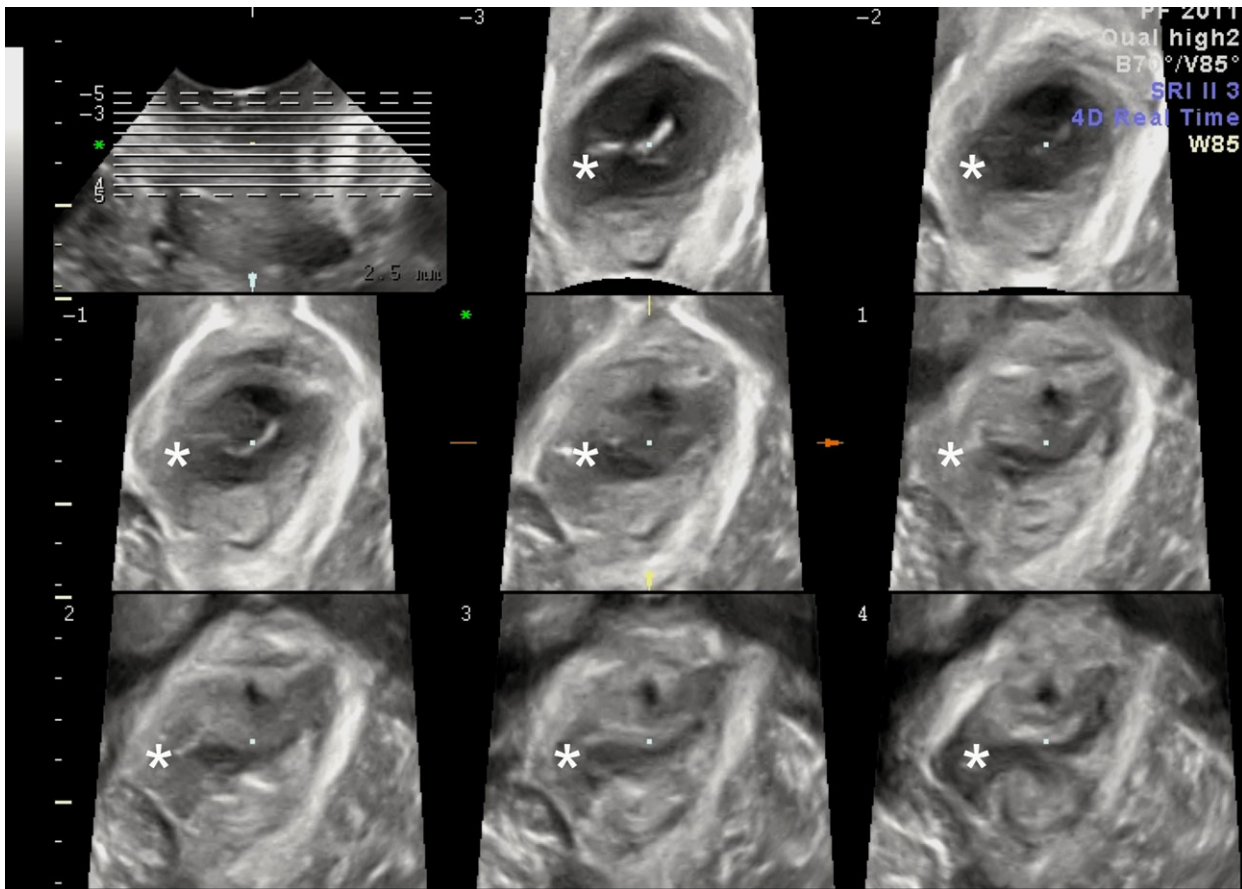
Tomographic image of a complete right-sided avulsion is indicated by (*) in slices 1–7. The volume was acquired on pelvic floor muscle contraction, during transperineal ultrasound with the probe in the midsagittal plane. The interslice interval is set at 2.5 mm. [Color figure can be viewed at wileyonlinelibrary.com].
